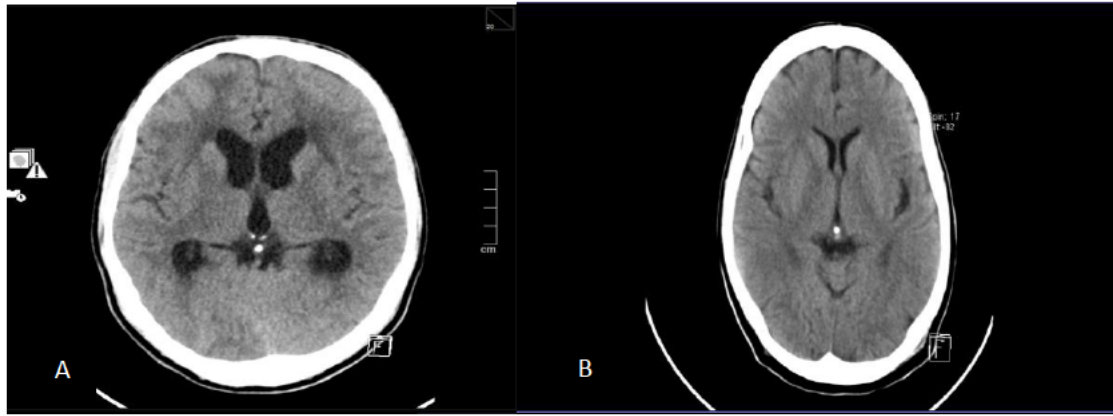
Non-contrasted CT brain scan of typical HIV patients with intracranial hypertension secondary to cryptococcal meningitis showing dilated ventricles (A) and normal sized ventricles (B)
